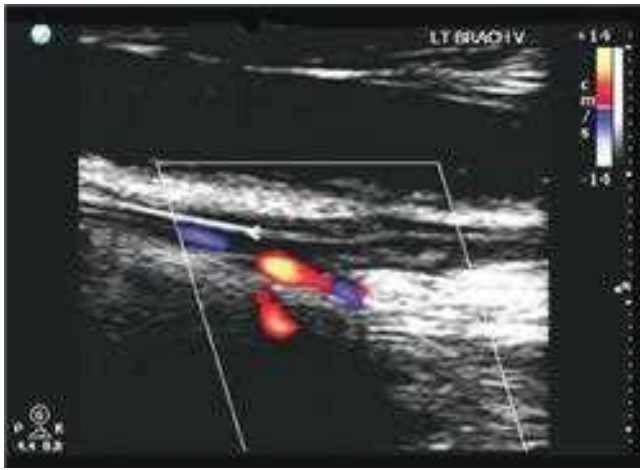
Duplex ultrasound of a brachial vein containing thrombus and percutaneously inserted central catheter (PICC).
